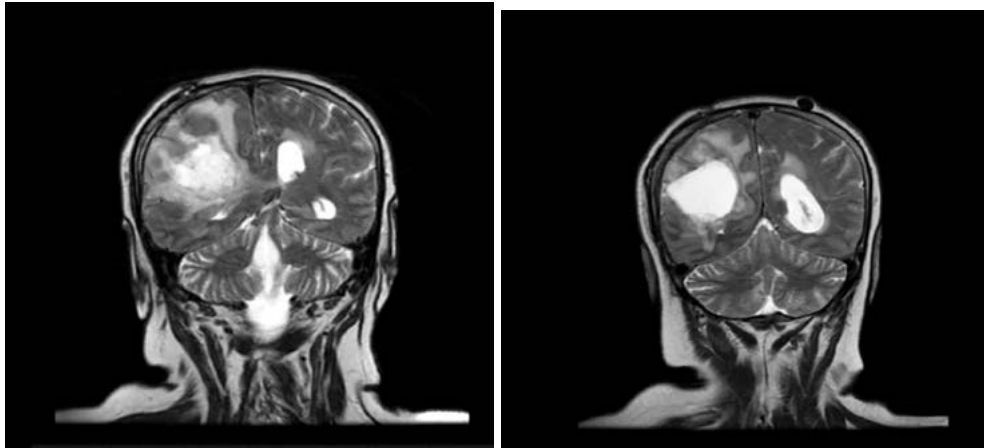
A heterogeneous, hyperintense space-occupying lesion in the right parieto-temporal region with marked perifocal oedema (glioblastoma; T2-weighted MRI, coronal sections).
